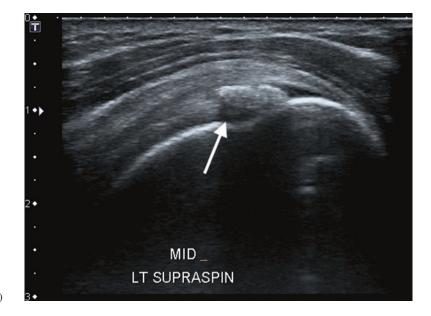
Ultrasound of a calcific tendinosis of the supraspinatus tendon demonstrating internal echogenic focus with posterior shadowing (*arrow*)
